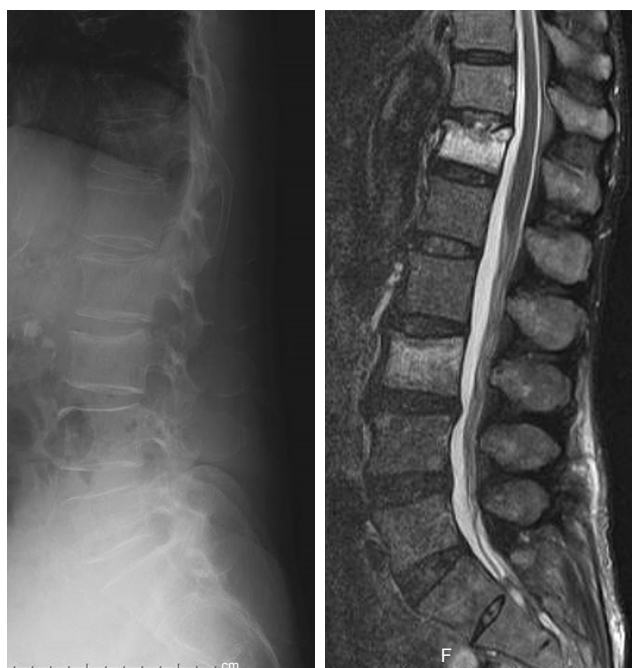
Plain lateral radiographs and MRI demonstrated a fresh vertebral fracture at L3 and T12.
